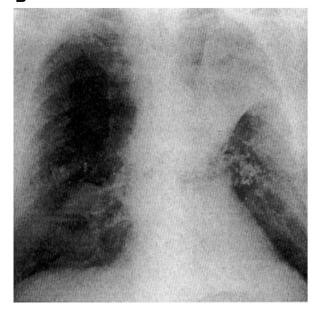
(A,B) Chest X-ray and endoscopic view of a malignant stenosis of the left lower lobe.
